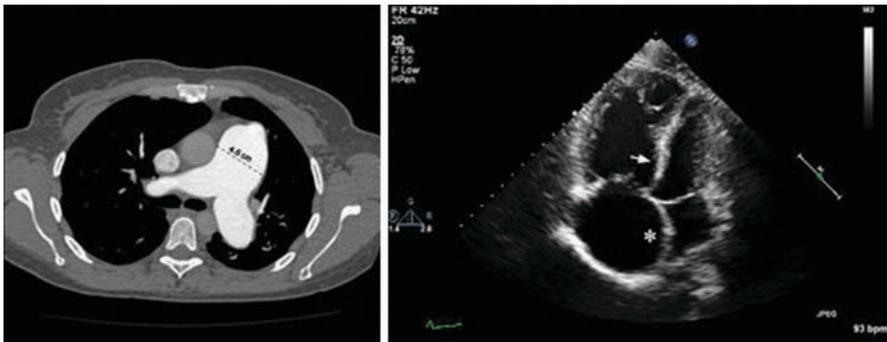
Imaging from a patient with Meth-APAH secondary to a 20-year history of methamphetamine use. Left panel: CT chest shows a massively enlarged main pulmonary artery measuring up to 4.5 cm. Right panel: Right ventricle (RV) focused apical four-chamber view at end systole from a 2D transthoracic echo shows severe RV dilatation with septal bowing into the left ventricle (arrow) consistent with RV pressure overload. The right atrium is severely enlarged with interatrial septum bowing into the left atrium (*)
